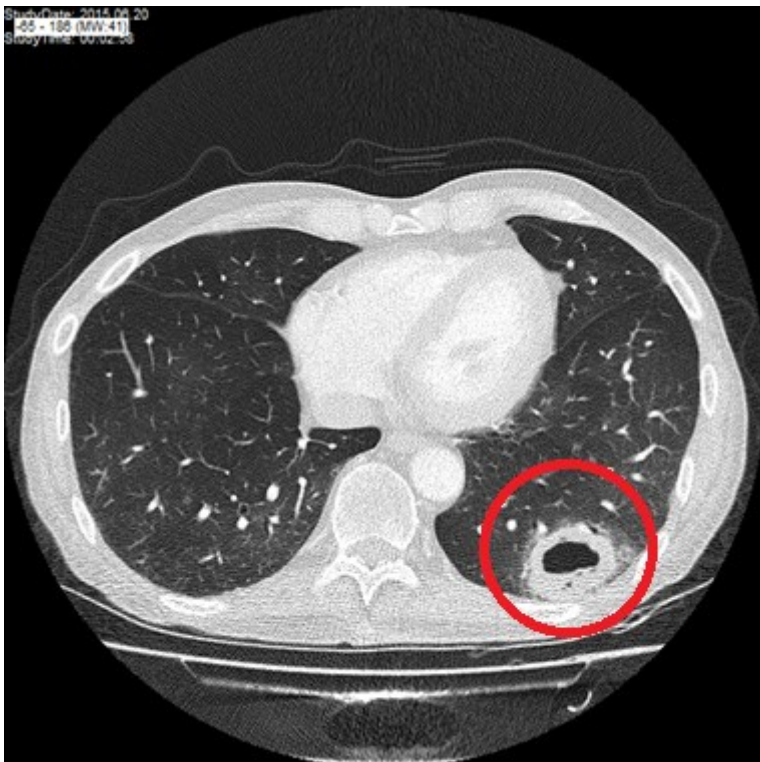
CT scan of the lung of F.S. from the 06/20/2015 showing a cavernous lesion in the left inferior lobe of the lung (red circle) with perifocal ground-glass infiltration of the lung parenchyma.
